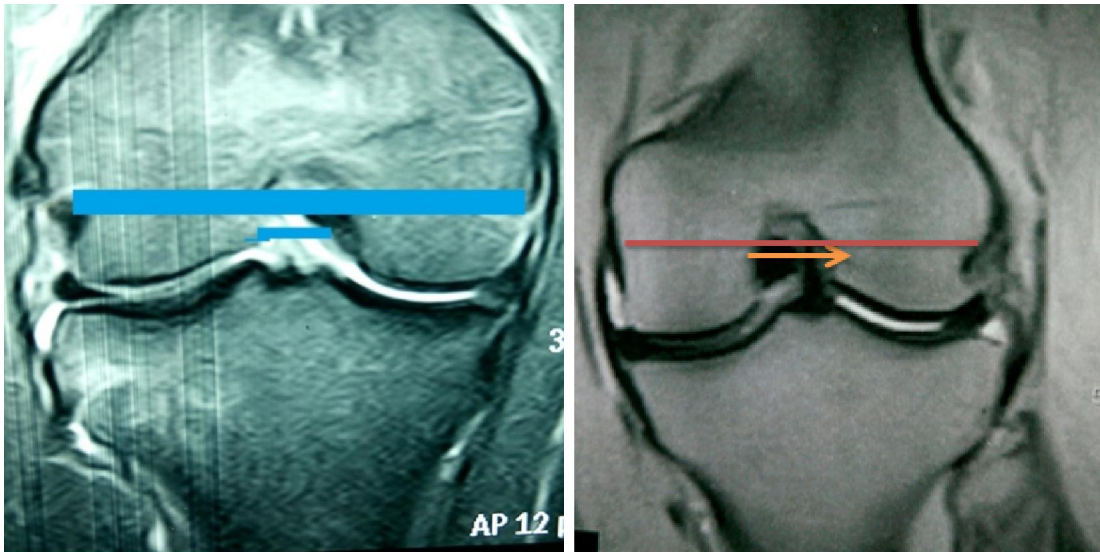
Coronal view of MRI at level of popliteal groove
